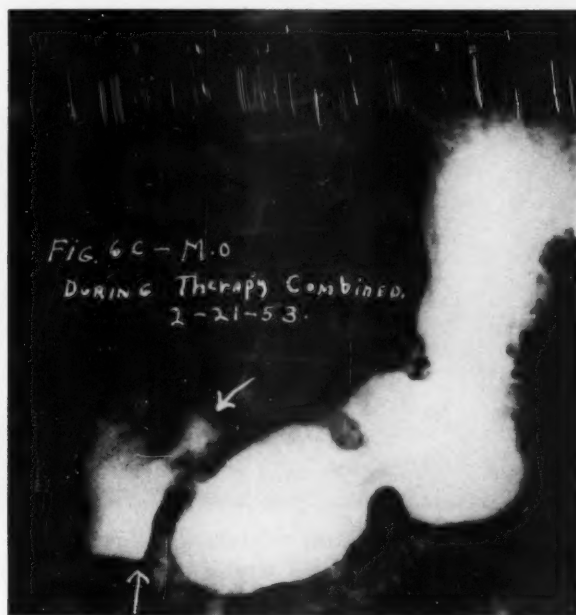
Six months after combined therapy (M. O.): Recurrence of direct x-ray signs during medical and psychoanalytical therapies. No improvement.
